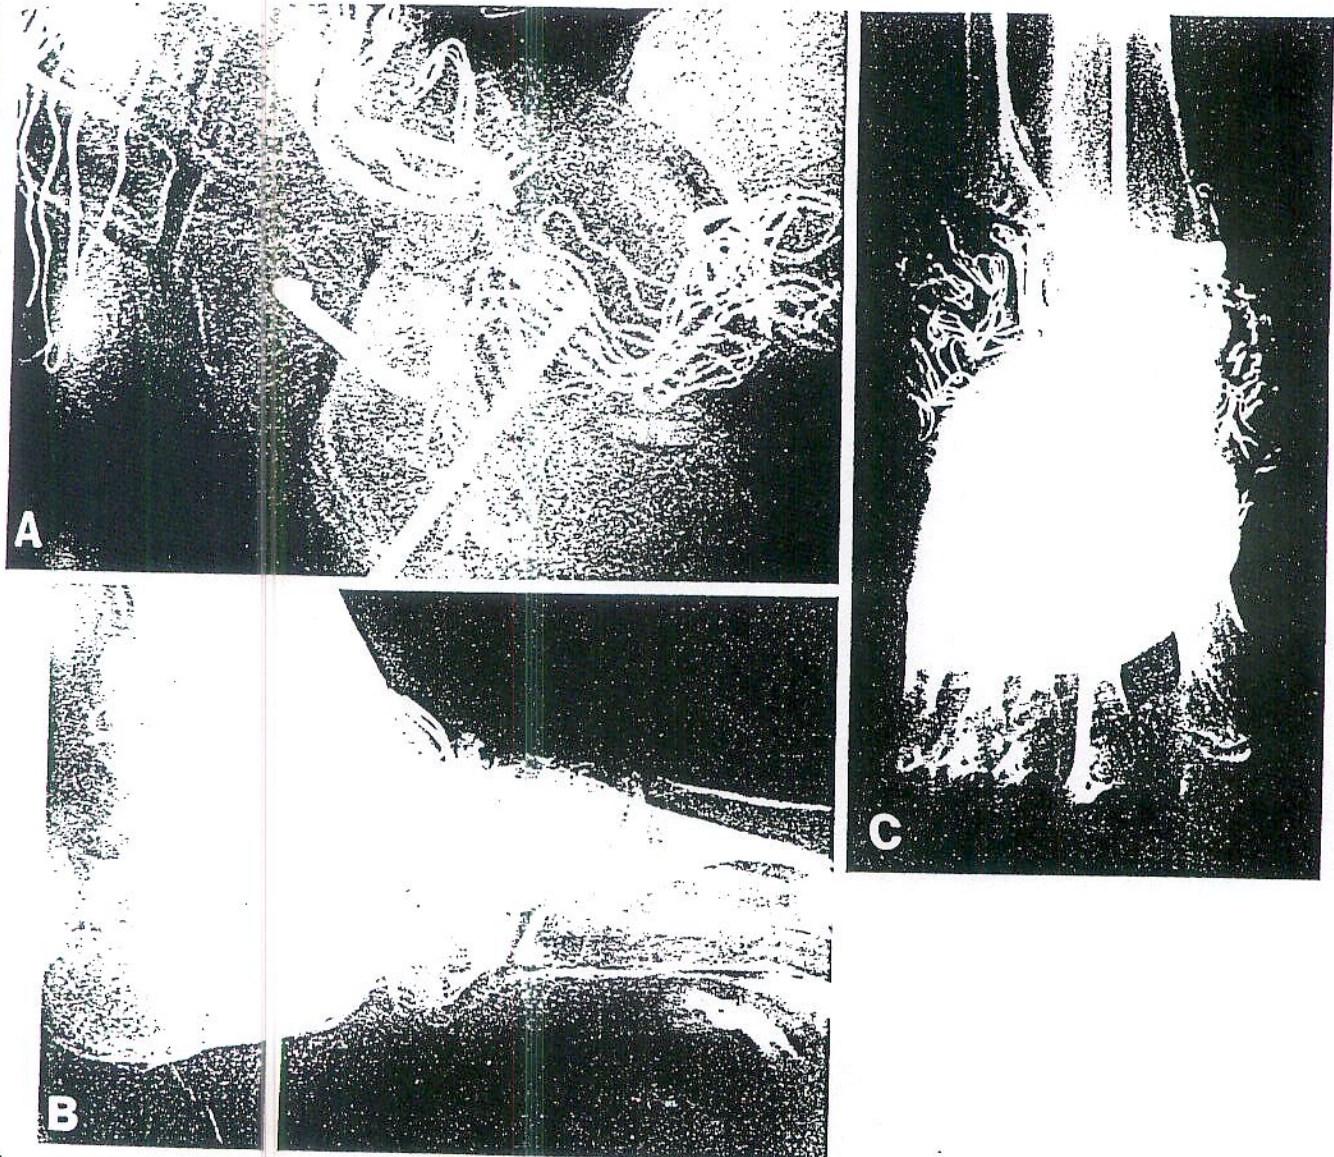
Intraoperative x-rays with bone grafting and internal fixation. A, lateral view of triple arthrodesis (wire mesh-marked spaces); B, lateral view of subsequent Chevrone procedure followed by advancement of axial compression pin and internal fixation with bone staple and bone screws; C, anteroposterior visualization of completed operation. (Note ankle joint is obliterated and medial onlay graft eliminates lateral ankle space.)
